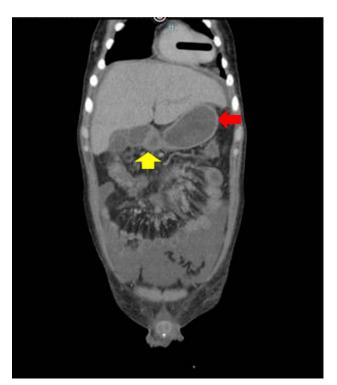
Coronal computed tomography imaging of the abdomen demonstrating dilation of the stomach (red arrow) and duodenal bulb (yellow arrow).
